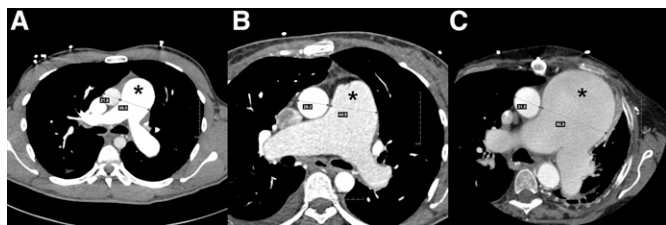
Dilated pulmonary artery (PA, indicated by the asterisk in each panel) on contrast-enhanced computed tomography (CT) of the chest. (A) A 22-year-old man with idiopathic pulmonary arterial hypertension (PAH). Mean PA pressure 83 mm Hg and pulmonary vascular resistance (PVR) 18.3 Wood units. Aorta and PA measure 21.8 and 39.5 mm, respectively. (B) A 46-year-old woman with PAH due to congenital heart disease had a ventricular septal defect corrected at the age of 5 years. Right heart catheterization at the time of CT scan showed mean PA pressure of 55 mm Hg with a PVR of 12 Wood units. Aorta and PA measure 29.3 and 44.9 mm, respectively. (C) A 64-year-old woman with chronic thromboembolic portopulmonary hypertension after pulmonary thromboendarterectomy. Due to severe (80%) extrinsic compression of the left main coronary trunk she required percutaneous coronary intervention with stent placement. Mean PA pressure 55 mm Hg and PVR 7.5 Wood units. Aorta and PA measure 31.5 and 80.0 mm, respectively.
